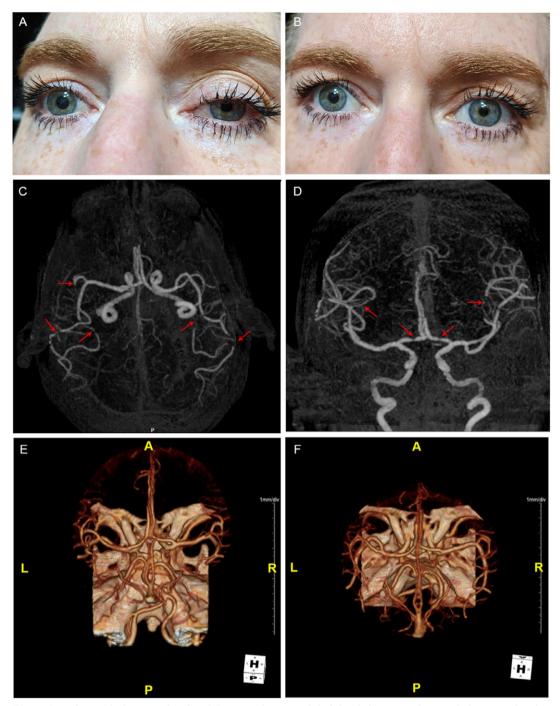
Before and after apraclonidine 0.5 mg eye drop: (A) (left) left-sided ptosis and miosis before apraclonidine and (B) (right) improvement of ptosis after apraclonidine. CTA 3D maximum intensity projection (MIP) of anterior circulation (4th week after symptom onset): (C) (left) multifocal stenoses of M2 branches of both middle cerebral arteries and (D) (right) multifocal stenoses of A1 branches of both anterior cerebral arteries and M2 branches of both middle cerebral arteries. CTA 3D MIP coronal (E) (left) and axial (F) (right) view (reformatted) (12th week after symptom onset): intracranial circulation at follow-up showed complete resolution of stenoses.
